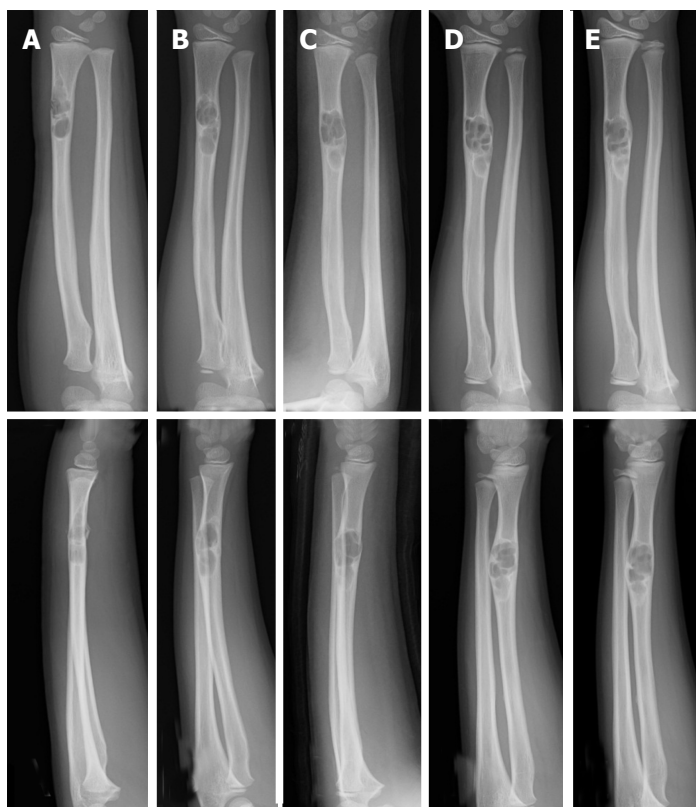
Plain radiographs of a non-ossifying fibroma in the radius of a 9-year-old male. At the initial assessment an osteolytic lesion in the distal radius is shown with an osteosclerotic rim. Fracture of the irregular adjacent cortex is revealed (A). Radiographs taken after 11 mo (B), 2 years and 1 mo (C), 2 years and 5 mo (D), and 3 years (E). The size of the lesion increased and ossification at the distal end was observed (plain radiographs: Anteroposterior view, top; lateral view, bottom).
